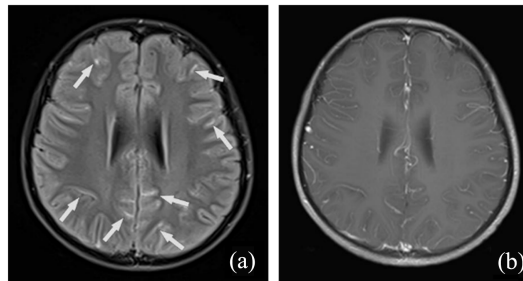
Case 4 MRI. An 11-year-old boy with vomiting and headache for two weeks. (a) MR enhanced T2WI-FLAIR sequence showed multiple linear enhancement of the pia mater with meningitis; (b) It is difficult to distinguish the meningeal enhancement with enhanced T1WI sequence from the blood vessels on the brain surface, so it is difficult to show lesions in the T1WI sequence.
